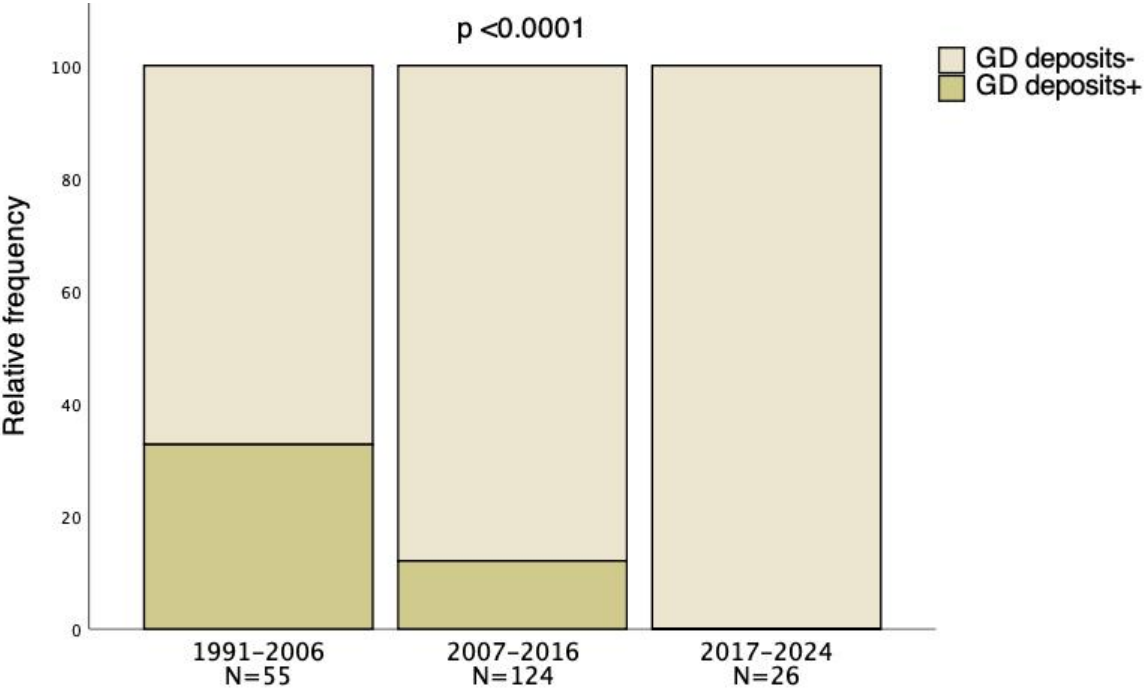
Bar-charts showing the relative frequency of brain Gd deposits according to the initiation era of the MRI monitoring. Gd, gadolinium.
